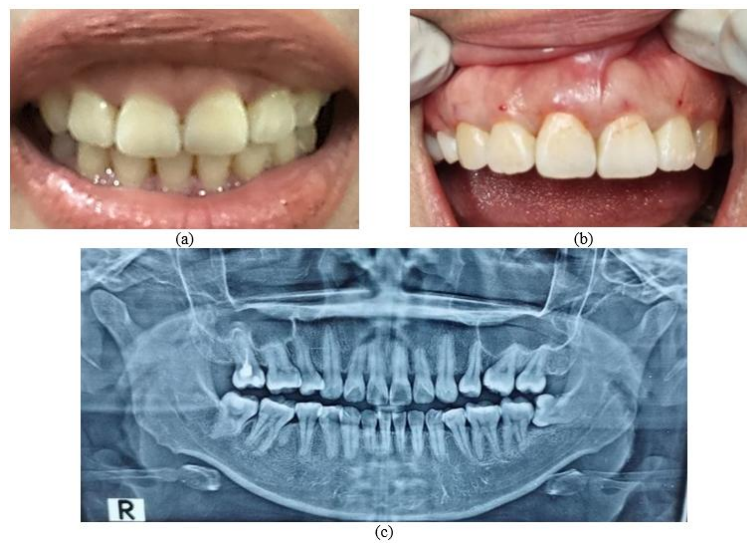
(a). Patient's gummy smile (b). Adequate attached gingiva (c). Panoramic radiograph
